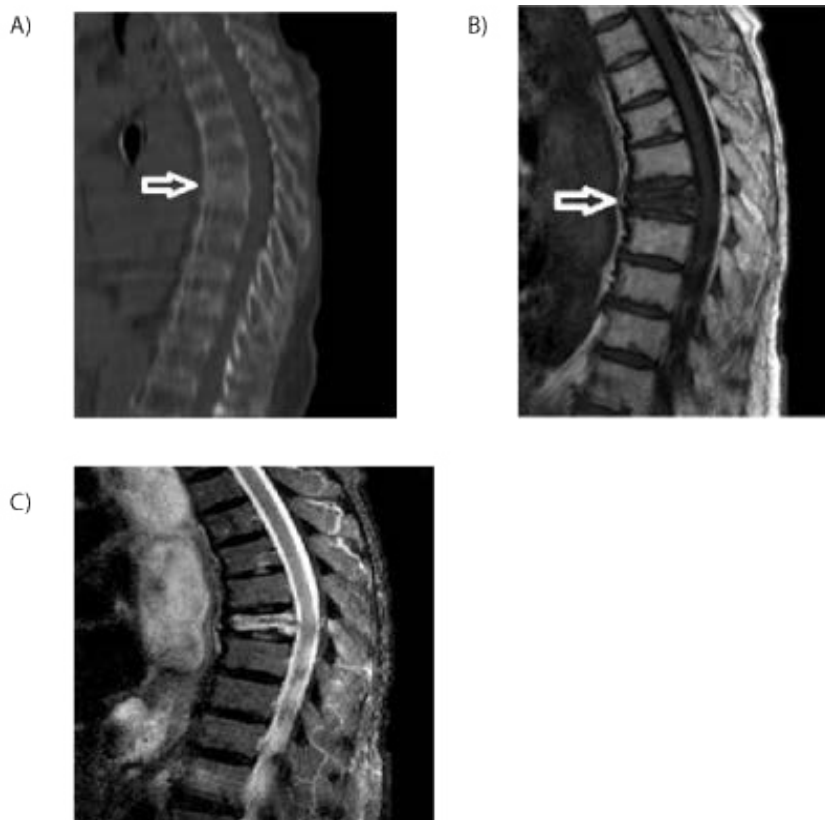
50% compression fracture of the T7 vertebrae on sagittal CT (A), sagittal T1 (B) and T2 (C) weighted MRI images.
